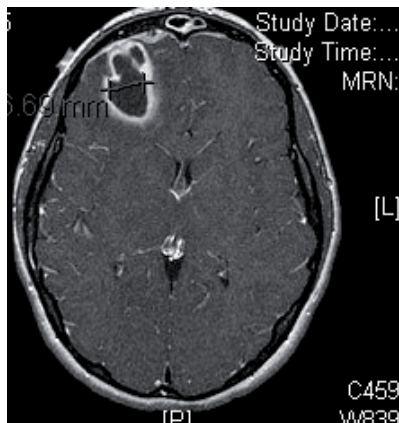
MRI with contrast, showing enhancing abscess within right frontal lobe.
